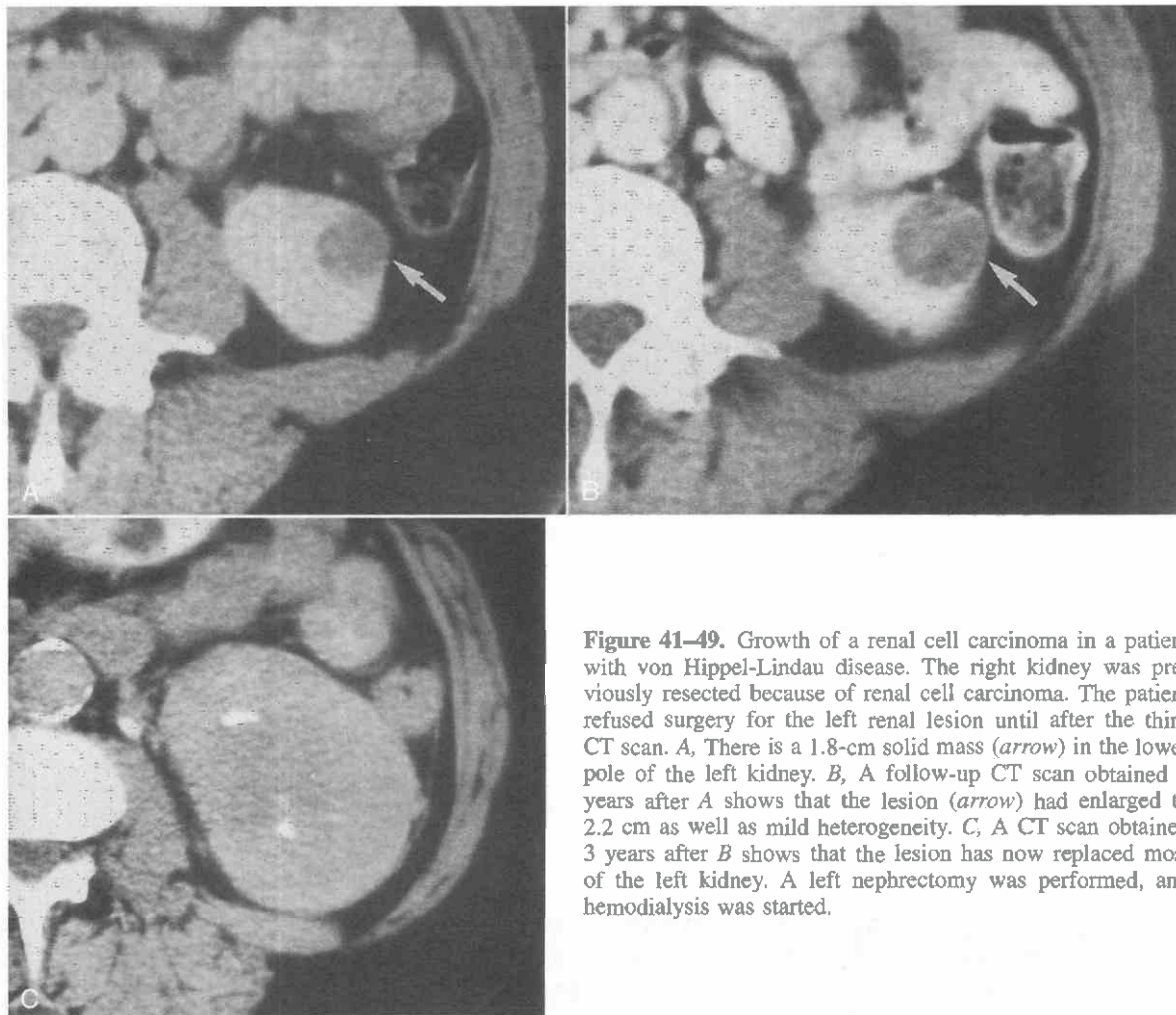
Growth of a renal cell carcinoma in a patient with von Hippel-Lindau disease. The right kidney was previously resected because of renal cell carcinoma. The patient refused surgery for the left renal lesion until after the third CT scan. *A*, There is a 1.8-cm solid mass (arrow) in the lower pole of the left kidney. *B*, A follow-up CT scan obtained 2 years after *A* shows that the lesion (arrow) had enlarged to 2.2 cm as well as mild heterogeneity. *C*, A CT scan obtained 3 years after *B* shows that the lesion has now replaced most of the left kidney. A left nephrectomy was performed, and hemodialysis was started.
